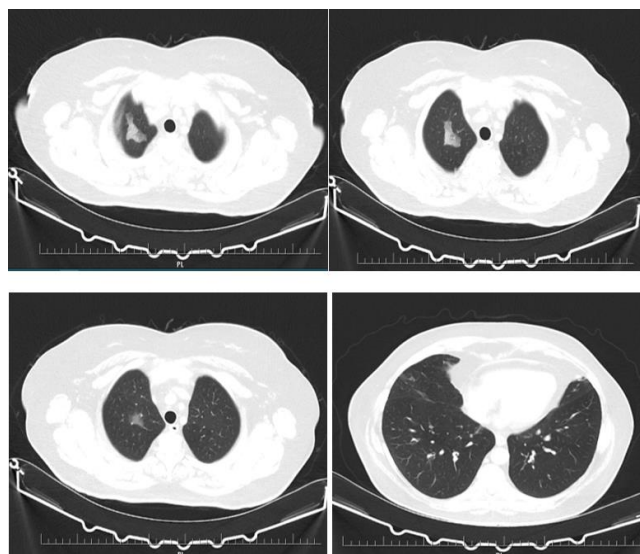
Thoracic CT on admission: Patchy ground-glass opacities in a crazy-paving pattern localized to the apical segment of the right upper lobe. Findings were suggestive of organizing pneumonia, consistent with EVALI. No significant lymphadenopathy or pleural effusion were noted
